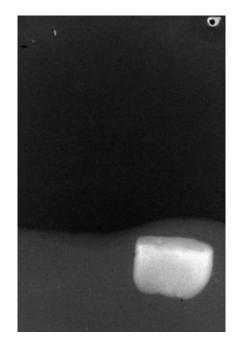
Radiograph of fragment in lower lip.
